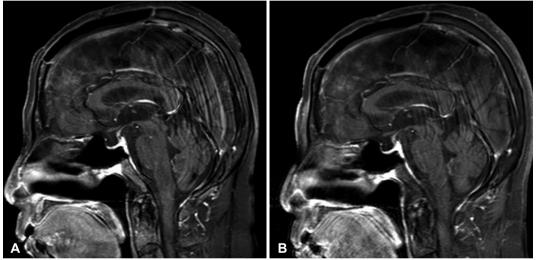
Postoperative follow-up magnetic resonance imaging. A: The contrast-enhanced sagittal T1-weighted image taken 8 weeks after surgery shows good resection of the tumor. B: The contrast-enhanced sagittal T1-weighted image taken 9 months after surgery shows that there is no tumor recurrence.
